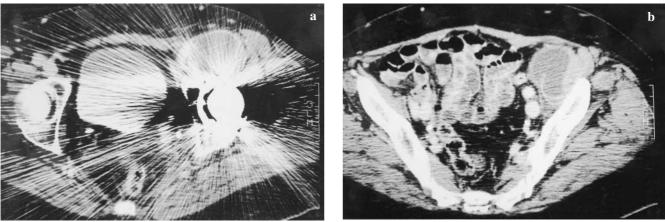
CT demonstration of the cystic dilatation of the iliopsoas bursa (a) dissecting between muscles up to iliac crest (b)
